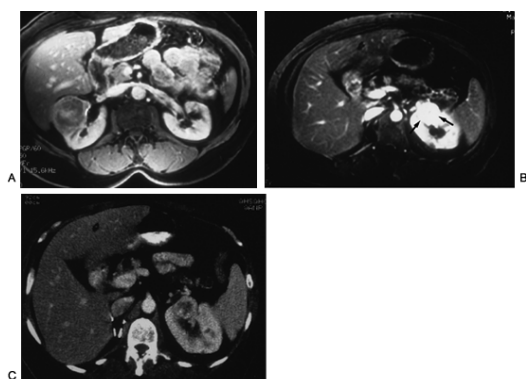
9. Gadolinium-enhanced magnetic resonance imaging (MRI) contrasting a hypovascular and a hypervascular tumor. A: Hypovascular solid renal mass is easily seen on this fat-suppressed gadolinium-enhanced MRI. B: Hypervascular mass (arrows) in another patient is more difficult to see on this dynamic enhanced fat-suppressed MRI. C: The computed tomography (CT) scan of the lesion in B readily depicts the lesion. Lesions tend to enhance more on MRI than on CT.
